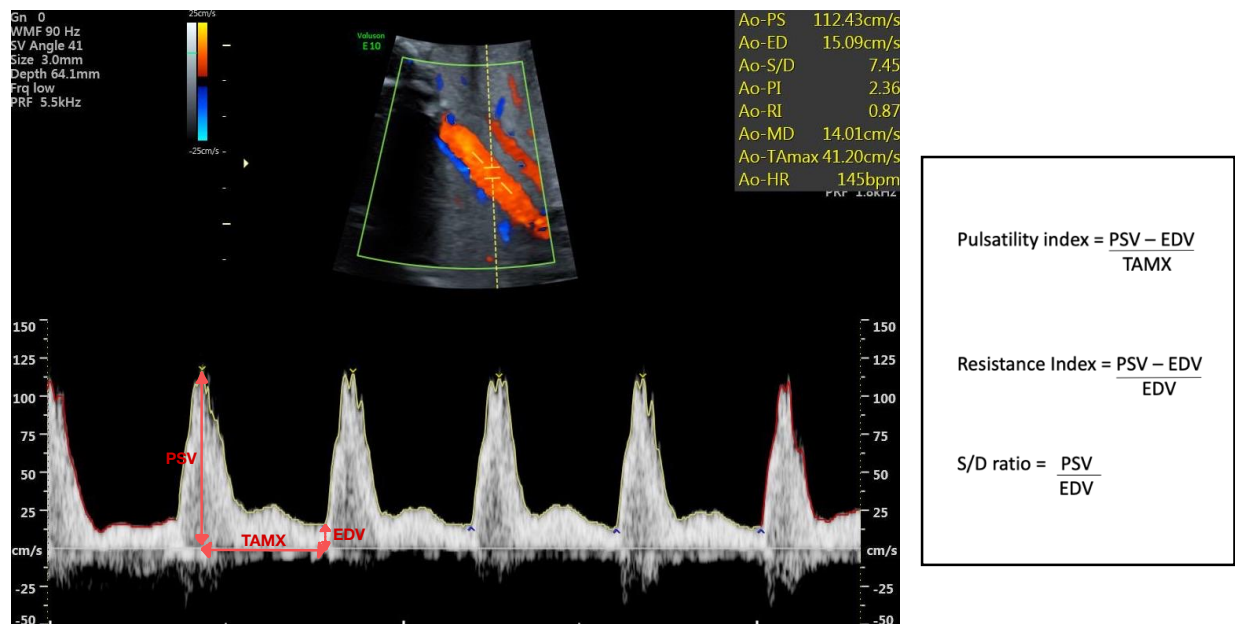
Doppler ultrasound of an aortic artery with the x- axis measuring the time and the y-axis measuring the velocity. The values of PSV, EDV and TAMX are identified. These are essential for the calculation of the Doppler indices described previously. The peak systolic velocity corresponds to the maximum velocity value obtained during systole, which in this case corresponds to 112.43 cm/s. The end diastolic velocity is associated with the smallest velocity value just before the beginning of another systole, that is marked as 15.09 cm/s, in this case. The TAMX corresponds to the time average maximum velocity, which is the time between the PSV and EDV, that in this case is 41.20 cm/s
